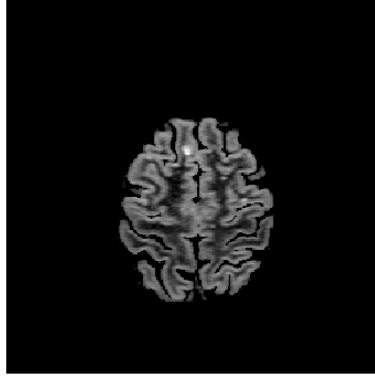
Zero level set, initialization and evolution of the first level set superimposed to the corresponding FLAIR image: initialization; evolution after one iteration; evolution after four iterations; final configuration.
